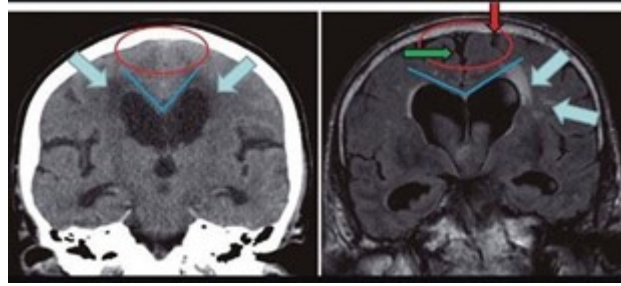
CT scan of head: coronal views. Left image: NPH. Right image: brain atrophy (hydrocephalus ex vacuo). Blue lines are indicating callosal angle. In the red circle, sulci are shown which are prominent in brain atrophy. Source: Figure by authors.
